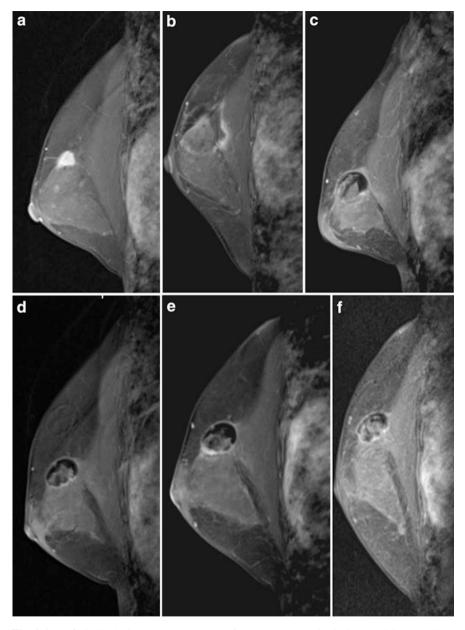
(a–f) Sagittal views on MRI scans before (*Pre*) and 1, 6, 12, 24, and 36 months in a 65 -year-old woman with a 15×10 mm-sized invasive ductal cancer who underwent RFA followed by whole-breast irradiation and endocrine therapy
